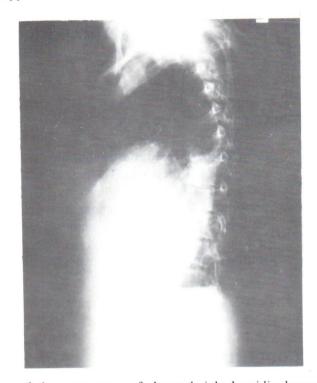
Plain film of the chest in AP and lateral views showed the appearance of elevated right hemidiaphragm VS a large mass at the lower half to the hemithorax, obliterating right hemidiaphragm.
